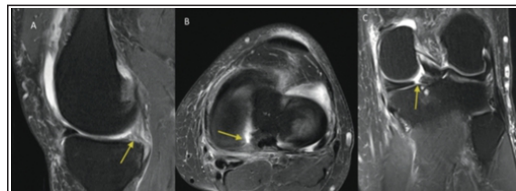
MRI T2 weighted images, a-sagittal-ghost sign, b-axial, c-coronal(truncation sign)
